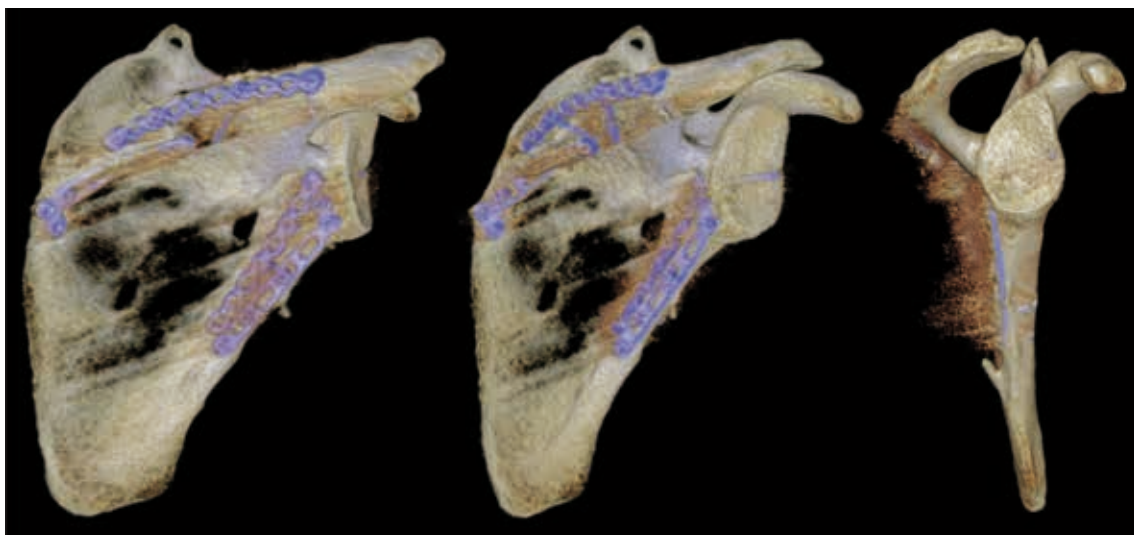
Follow-up 3D CT reconstructions 5 years postoperatively.
